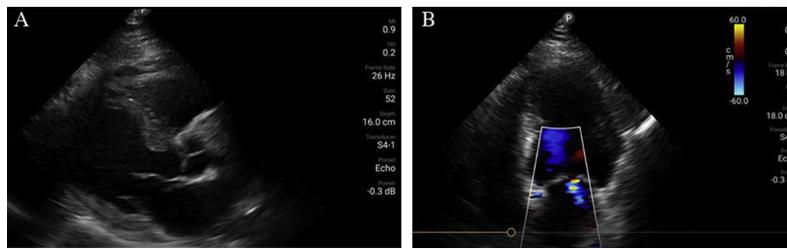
Sample images recorded using PSID: a) parasternal view, b) apical 4-chamber view – a color Doppler showing mild mitral regurgitation.
